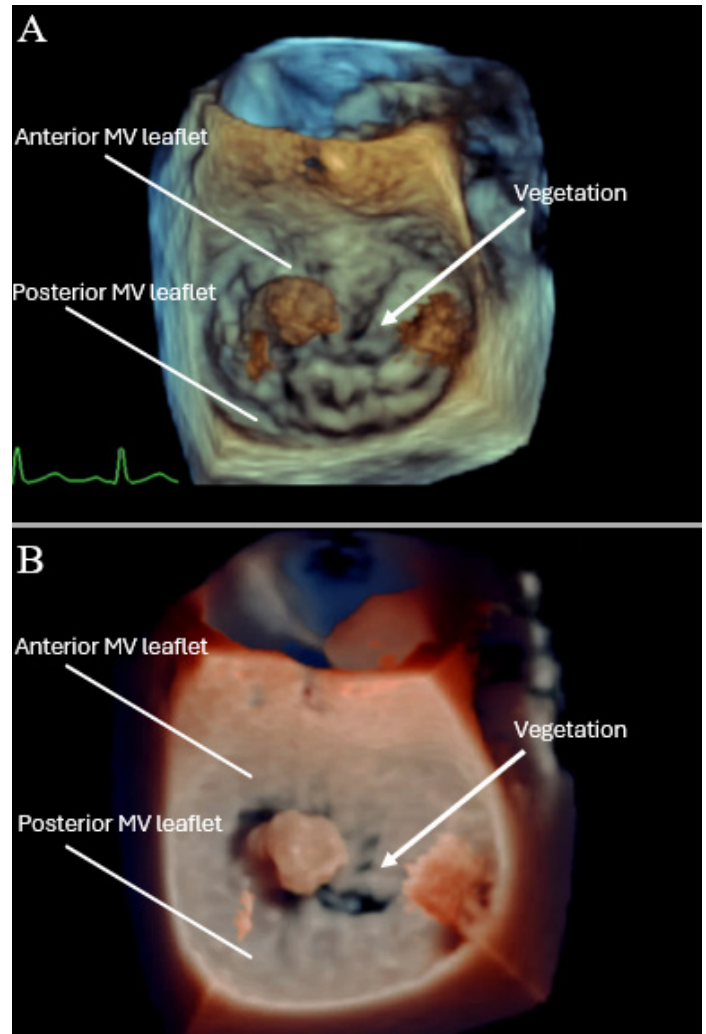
The image depicts two three-dimensional reconstructions of the transesophageal echocardiogram labeled A and B. These images show a 1.5 cm x 1.1cm homogenous, mobile mass attached to the anterior mitral valve leaflet that represents a vegetation. There is anterior leaflet perforation.
